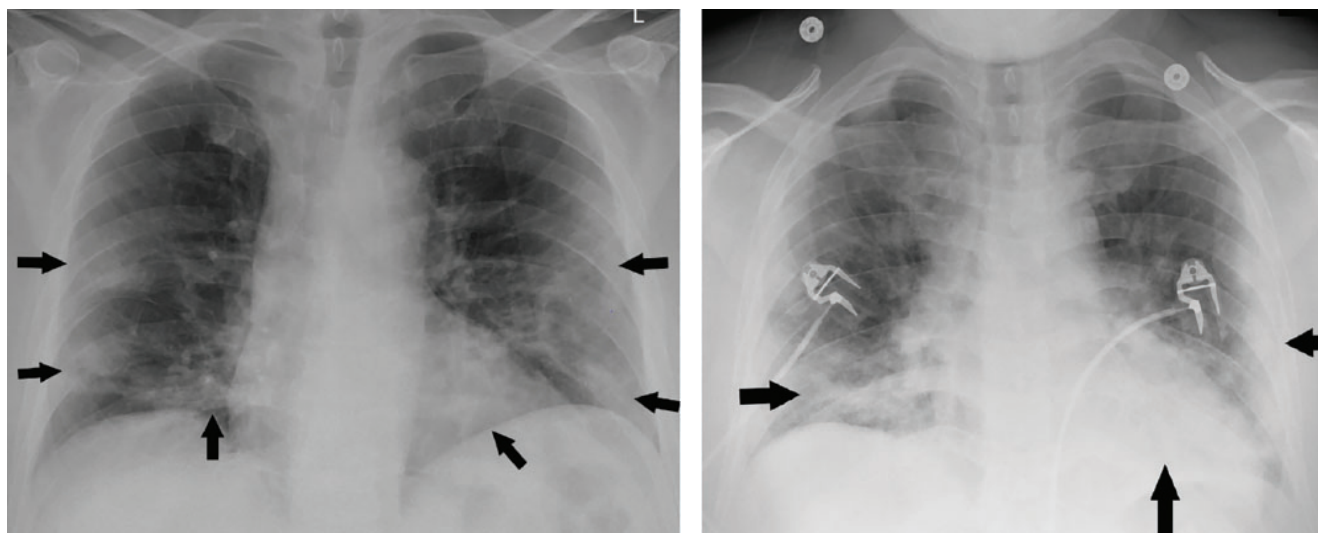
Portable chest radiographs of a patients with COVID-19 demonstrating classic bilateral, multifocal peripheral airspace opacities in the mid-lower-lung zones.
